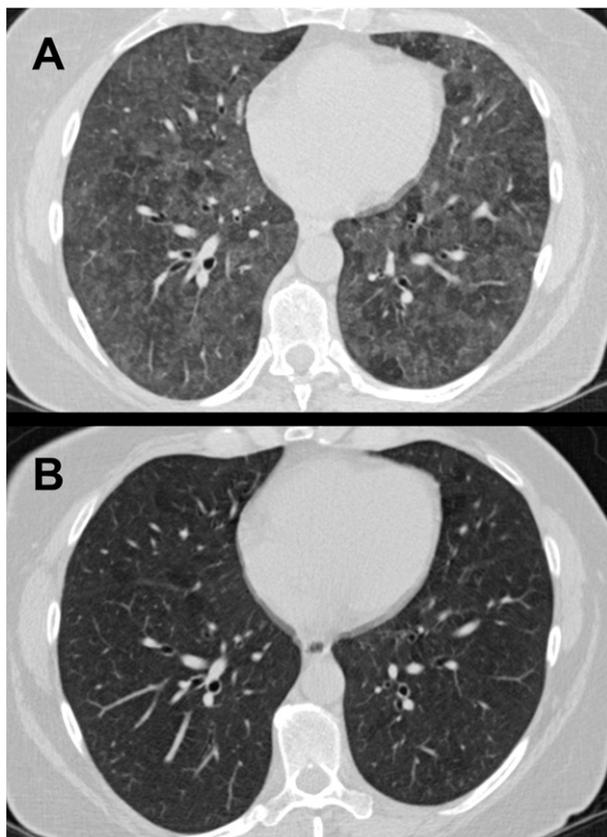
A, High-resolution CT scan of a patient with hot tub lung: patchy bilateral ground-glass opacities with poorly defined small centrilobular nodules. B, Same patient, 6 weeks following exposure withdrawal, showing full radiologic recovery.
